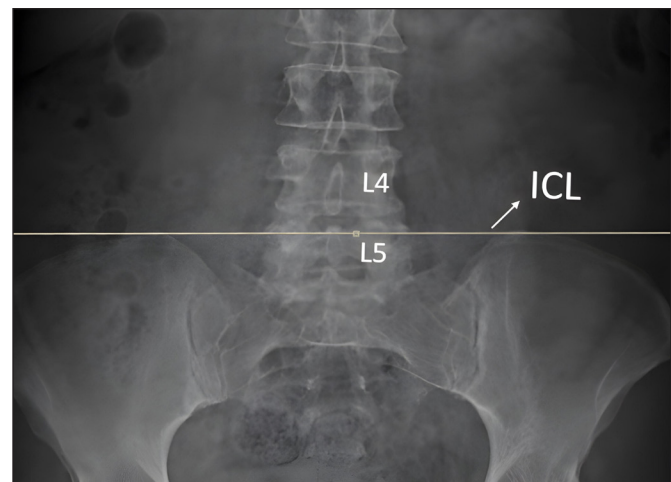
On the anteroposterior plain radiograph, the ICL passes through the L5 corpus (non-deeply seated L5 vertebra).
